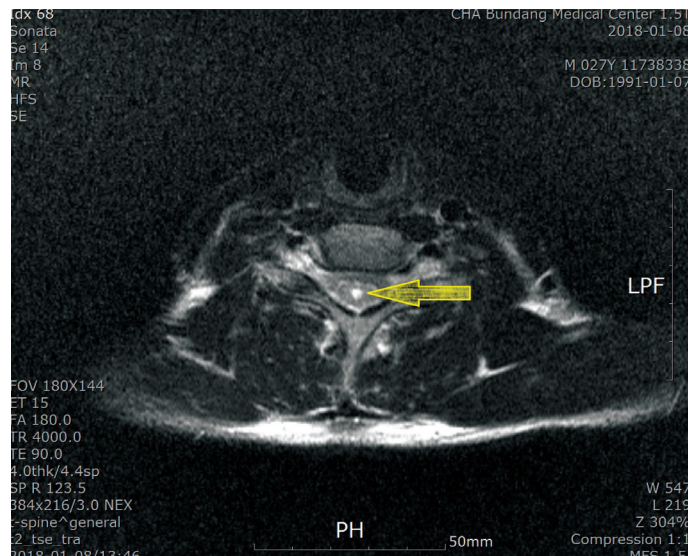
T2 weighted transverse plane of magnetic resonance imaging at the level C5-6 (2018-01-08). The cavity inside the central canal appears white.
